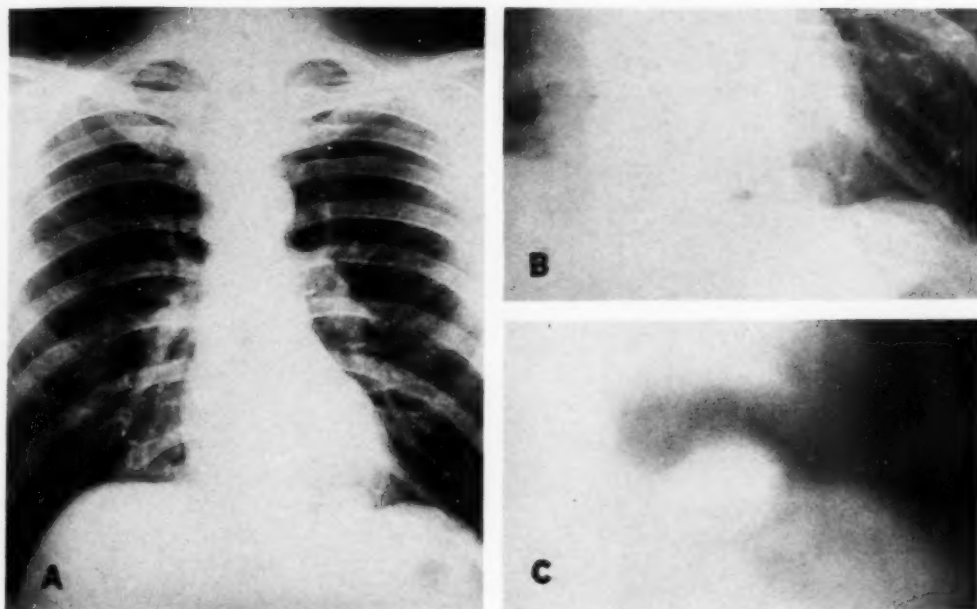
Case II. A. The mass is visible through the cardiac shadow in the area of the left hemidiaphragm. B. Enlargement of the area of the tumor. C. Body-section roentgenogram showing zone of lesser tissue density about the mass. This was interpreted as evidence that the tumor was separate from the diaphragm. It proved, however, to be a benign localized fibrous mesothelioma arising from diaphragmatic pleura.
